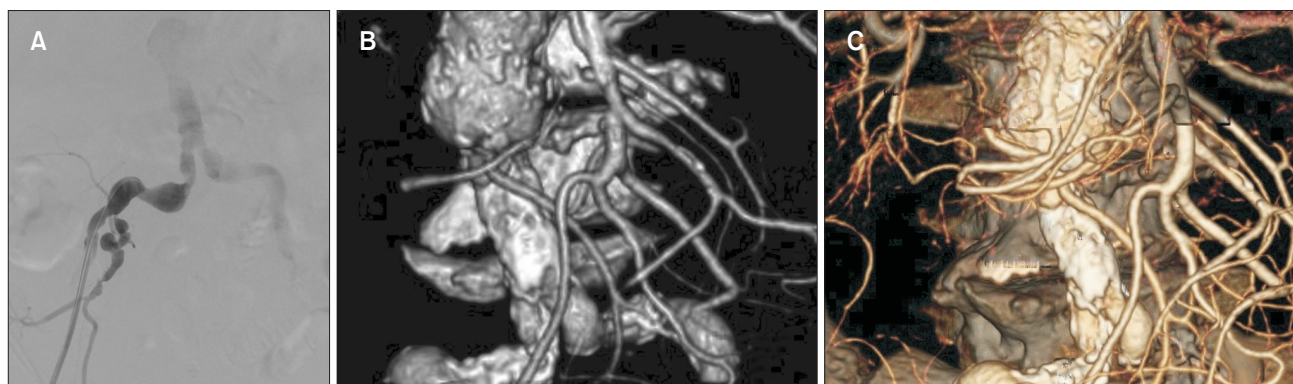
Iliac arteries angiography at the beginning of the procedure (A) and aorto-iliac 3D computed tomography scans (B, C) showed high-grade calcifications and moderate level of stenosis and tortuosity bilaterally.
